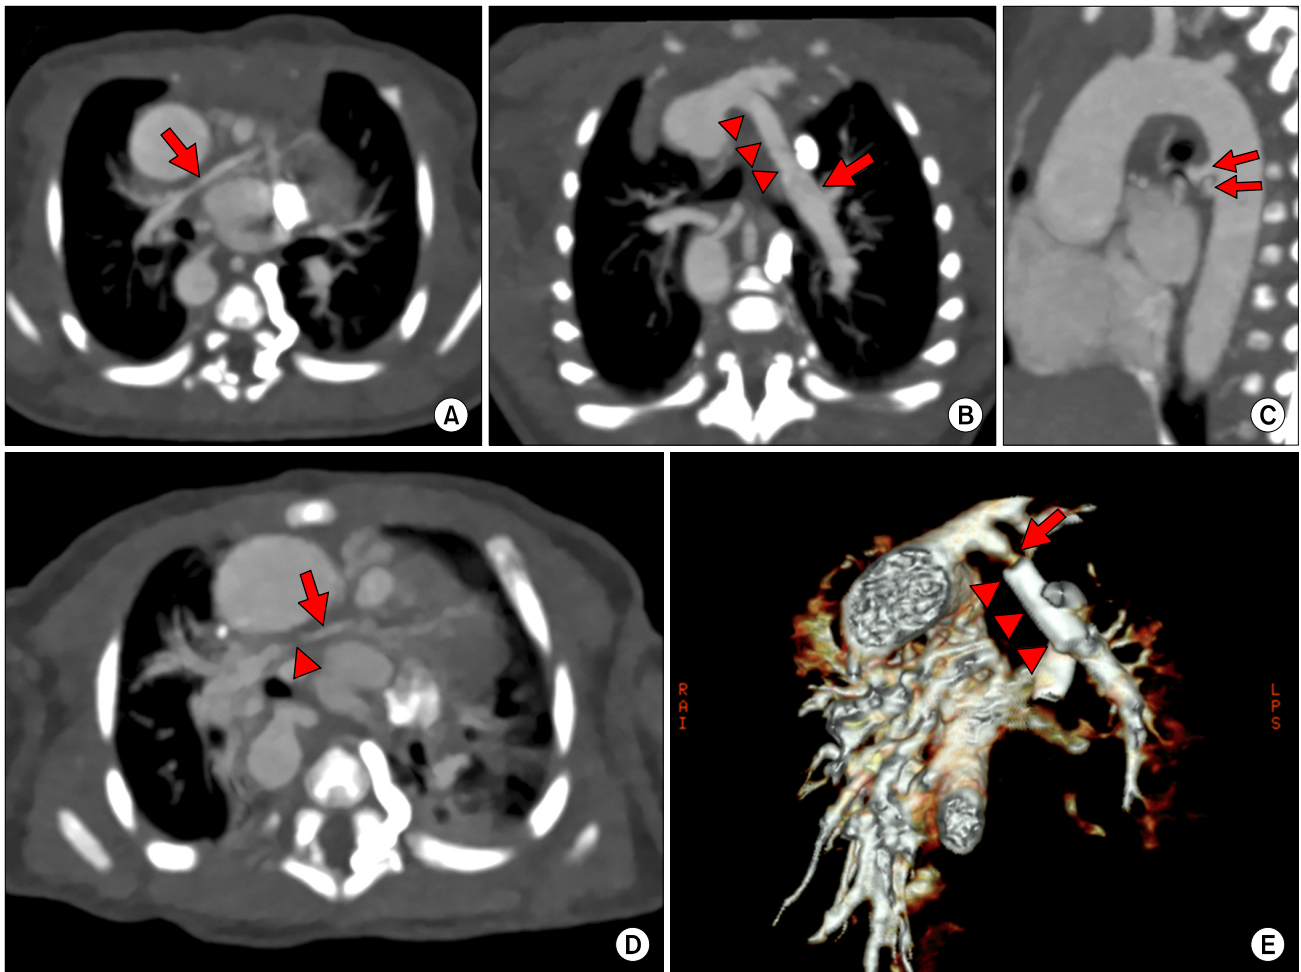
Initial and post-stent follow up heart CT. Figures A–C are the initial heart CT image at one day old. (A) Small RPA (arrow). (B) The left pulmonary artery (arrow) from the left PDA (arrowhead). (C) Two major aortopulmonary collateral arteries (arrow) are shown arising from the proximal descending thoracic aorta. Figures D and E are the follow-up heart CT image following PDA stent at 34 days of age. (D) Diminutive RPA (arrow) with focal stenosis (arrowhead) at the distal portion. (E) The left pulmonary artery distal to the PDA stent (arrowhead). Severe narrowing (arrow) is seen proximal to the PDA stent. CT, computed tomography; RPA, right pulmonary artery; PDA, patent ductus arteriosus.
